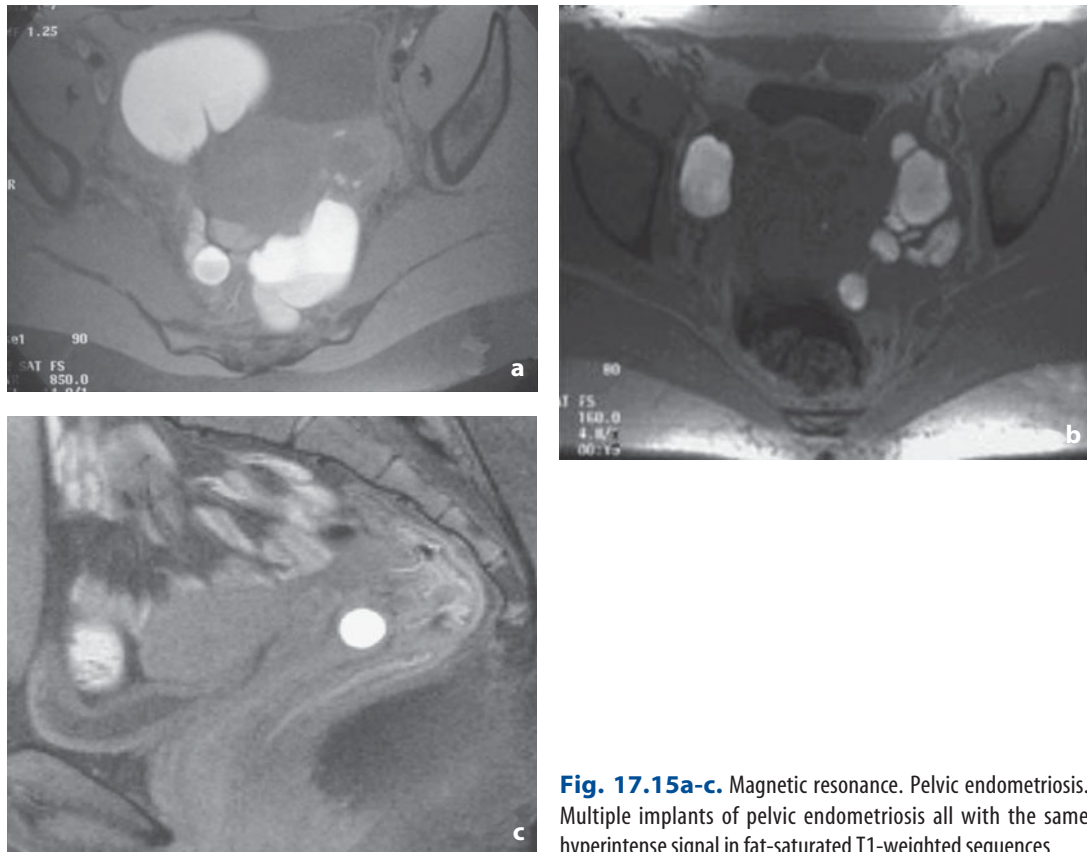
Magnetic resonance. Pelvic endometriosis. Multiple implants of pelvic endometriosis all with the same hyperintense signal in fat-saturated T1-weighted sequences
